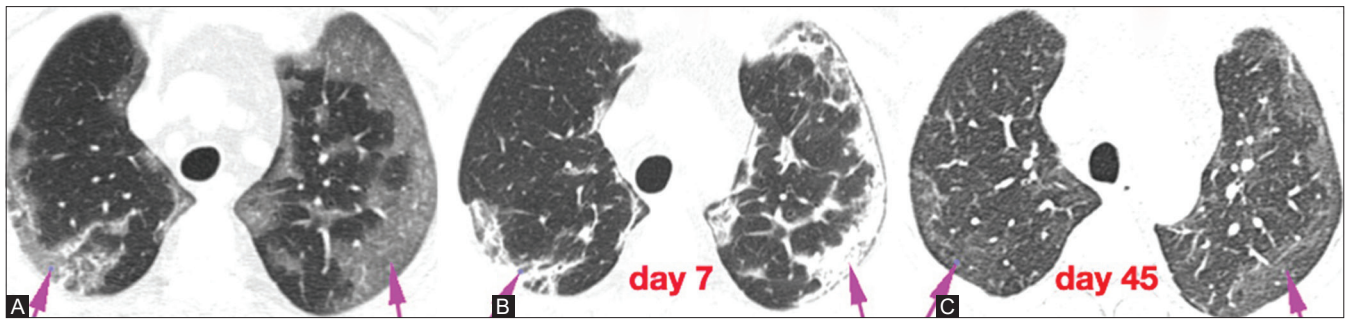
(A-C): HRCT (A) reveals typical subpleural ground-glass densities. HRCT (B) after 7 days of first scan reveals transition of ground-glass densities to dense consolidation with reticular opacities. HRCT (C) 45 days after first scan reveals nearly total resolution with minimal ground-glass densities
